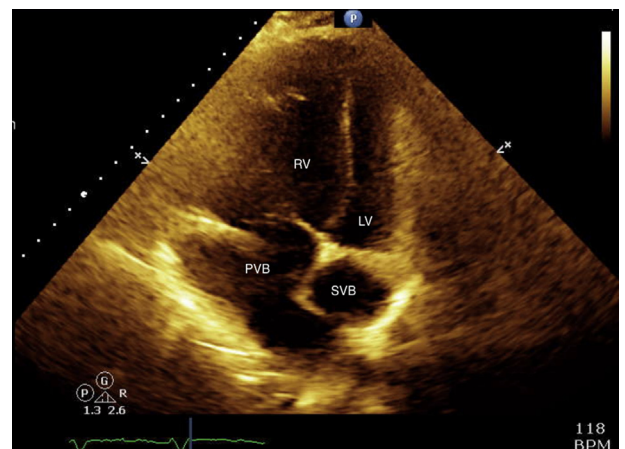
Transthoracic echocardiography, apical four-chamber view, showing the patient's unique anatomy of d-TGA following the atrial switch procedure. The morphologic right ventricle (RV) (systemic ventricle) is severely enlarged and hypertrophied, with bowing of the interventricular septum toward the morphologic left ventricle (LV) (subpulmonic ventricle). The pulmonary venous baffle (PVB) is well seen, whereas the more anterior systemic venous baffle (SVB) is not. There is no evidence of IE in this view.
